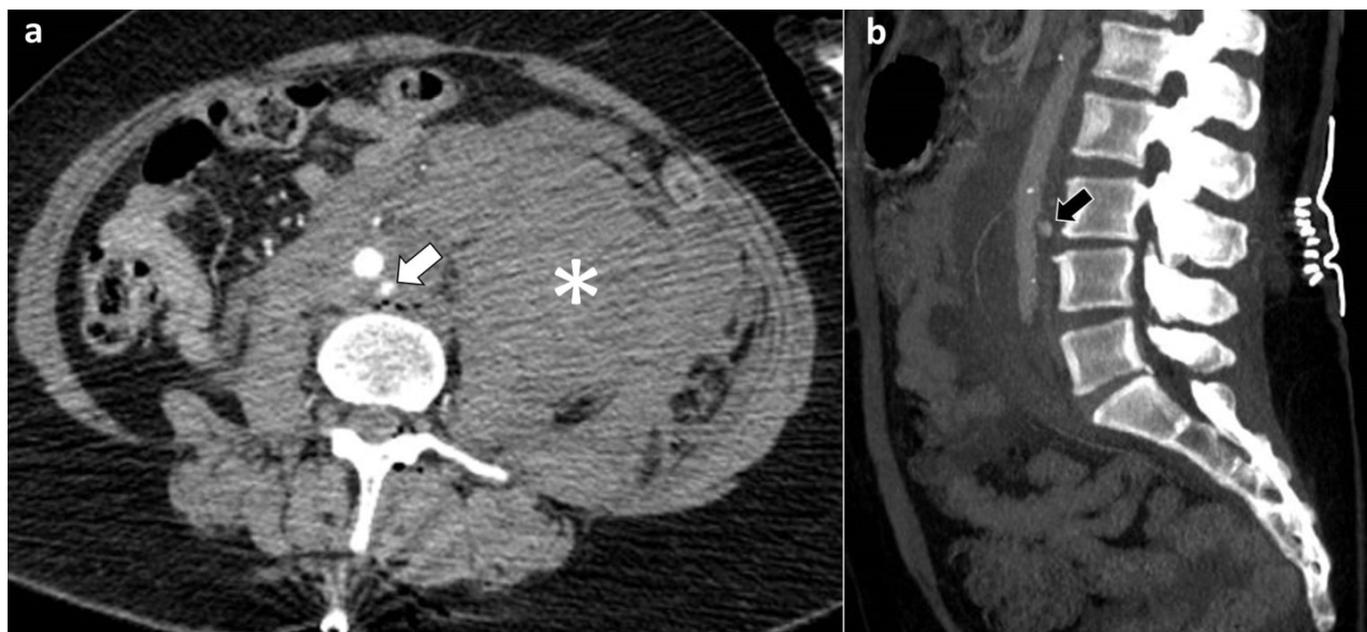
CT angiography depicting aortic rupture following lumbar discectomy. (a) Axial view showing contrast leak in the infrarenal aorta (white arrow), with massive retroperitoneal hematoma (asterisk); (b) Sagittal view showing contrast leak of the infrarenal aorta (black arrow) at L3-L4 level, relating to recent surgery site. Cutaneous staples are noted at this level.
